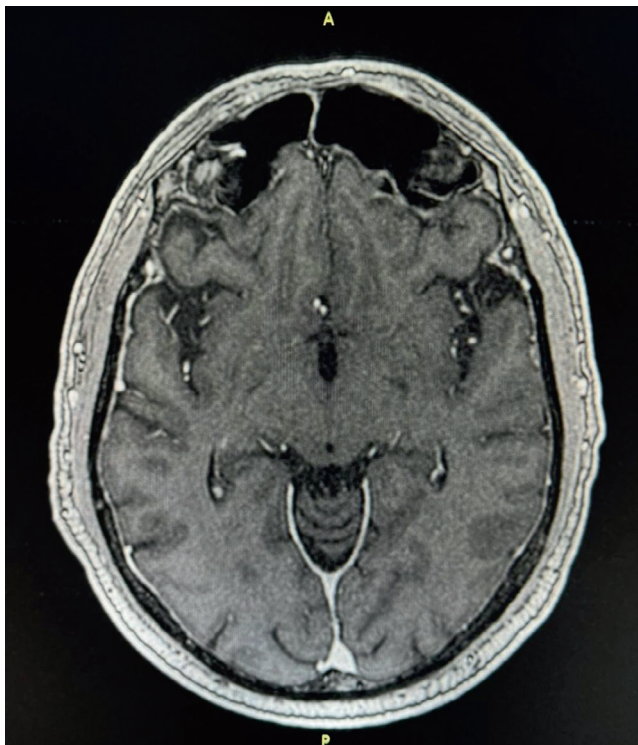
Patient's brain MRI T1 post contract sequence, axial projection -leptomeningeal post-contrast enhancement.
